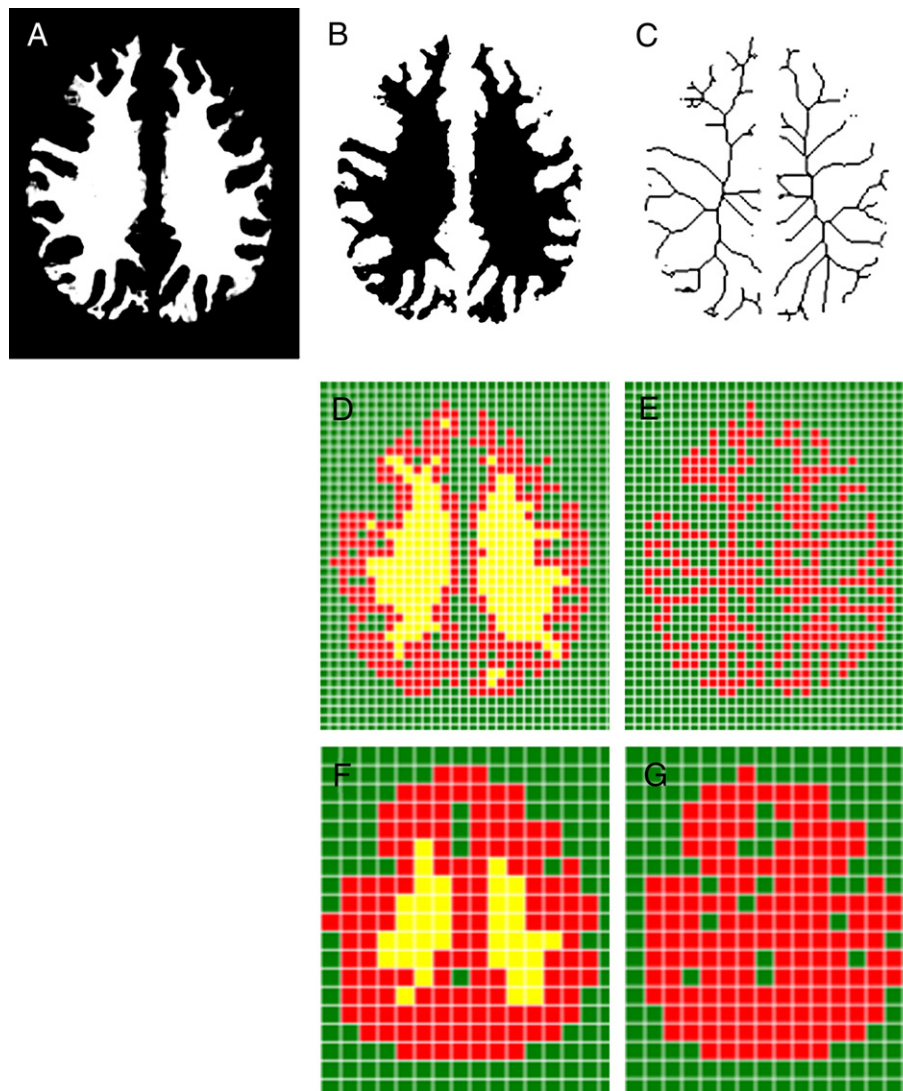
Box-counting method used to obtain the fractal dimension of MR images (data from one control subject) using HarFA software (<http://www.fch.vutbr.cz/lectures/imagesci>). (A) White matter image at the *centrum semiovale* level obtained after segmentation with SPM2. (B) Binary converted image from (A) after performing a full-range thresholding to exclude the black background (intensity selection from 1 to 255). (C) *Skeletonized* image obtained from (B) after applying a skeletonization algorithm. (D–G) A grid with different number of boxes (N) covered each image depending on the box size (r): (D) White matter border, $r=5$ pixels, $N=315$ (red boxes). (E) Skeleton, $r=5$ pixels, $N=323$ (red boxes). (F) White matter border, $r=10$ pixels, $N=133$ (red boxes). (G) Skeleton, $r=10$ pixels, $N=153$ (red boxes).
